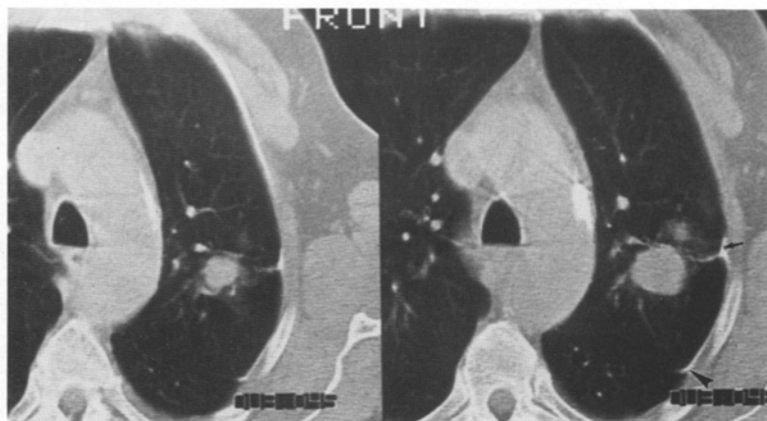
Thoracic CT scans of a patient with a lung carcinoma located approximately 15 mm subpleurally. The fibrin glue is shown thread-like in the biopsy needle track leading from the pleura to the lesion. Note the fibrin-glue plug forming a triangular plug in the subpleural region (arrow). A small leak into the pleural region is observed (arrow-head).
